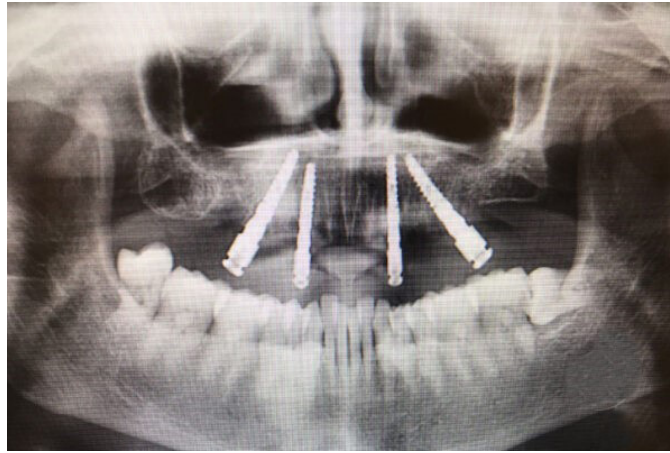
Radiographic Follow-up, 2 Months Later
